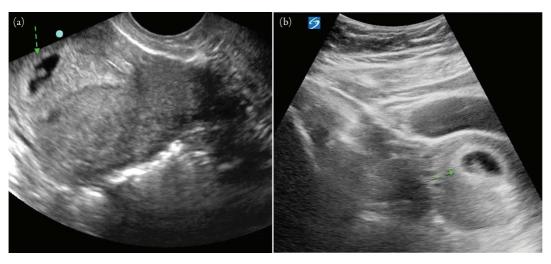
(a) Transvaginal ultrasound showing an intrauterine pregnancy (arrow). (b) Transabdominal ultrasound showing an intrauterine pregnancy (arrow).
